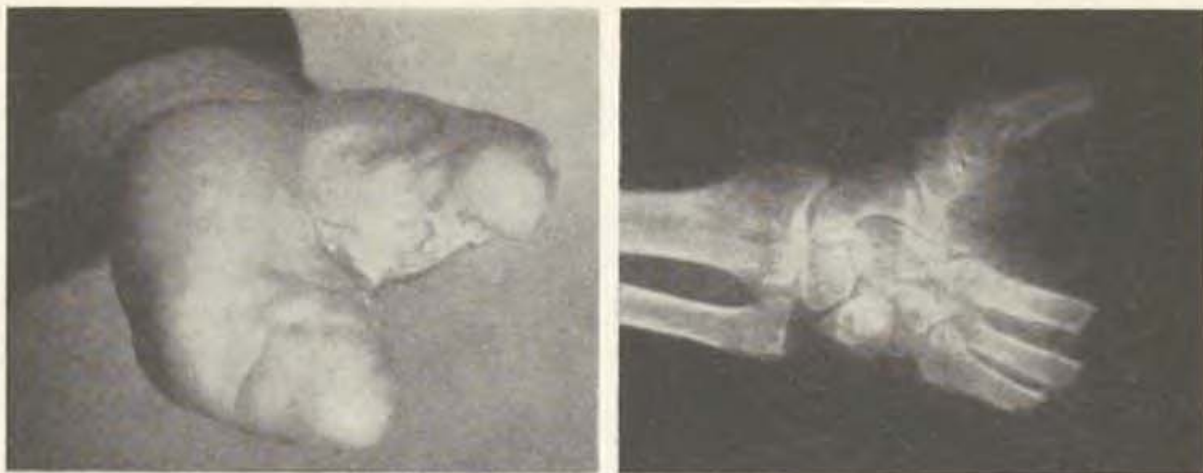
C: The state two months later. The patient can well move the reconstructed "thumb" from the other branch of the "grip" which is formed by the stumps of the third to the fifth metacarpal bone. — C1: X-ray in comparison with the state before the operation (A1)
